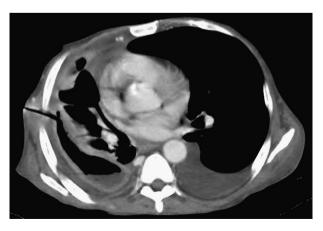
Chest computed tomography (CT) showing pleural effusion and right pleural thickening.
